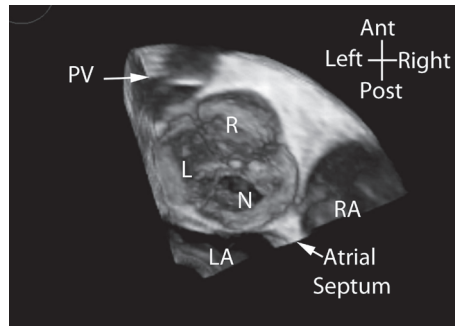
En face view of the normal aortic valve. Transoesophageal 3DE view of a normal aortic valve viewed from the aortic side of the valve.
